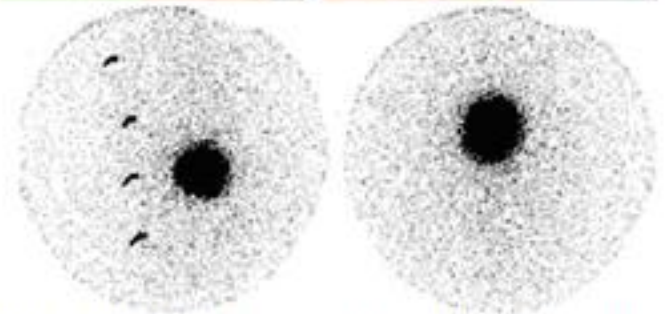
Lateral (left; marked neck surface) and anterior (right) scintigraphic imaging of radioactive iodine-131 concentrating tissue in the neck by using gamma camera equipped with pinhole collimator.
